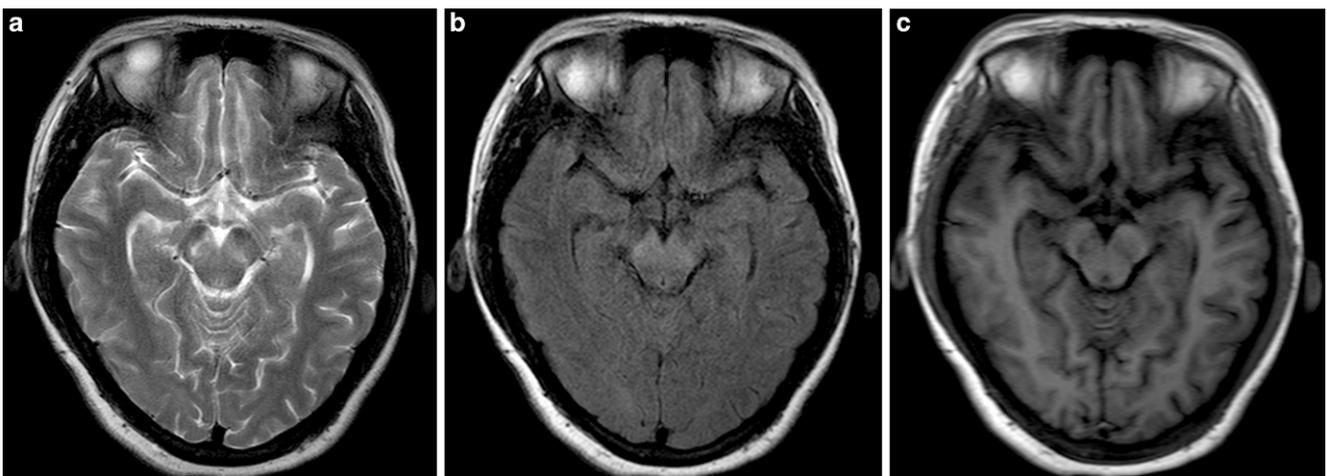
a Two months after discharge, the hyperintense lesions in the bilateral substantia nigra on T2-weighted imaging became more blurred, especially the lesion on the left side. b The hyperintense lesions on the fluid-attenuated inversion recovery sequences also became more blurred. c The hypointense lesions in the bilateral substantia nigra on T1-weighted imaging also became more blurred
